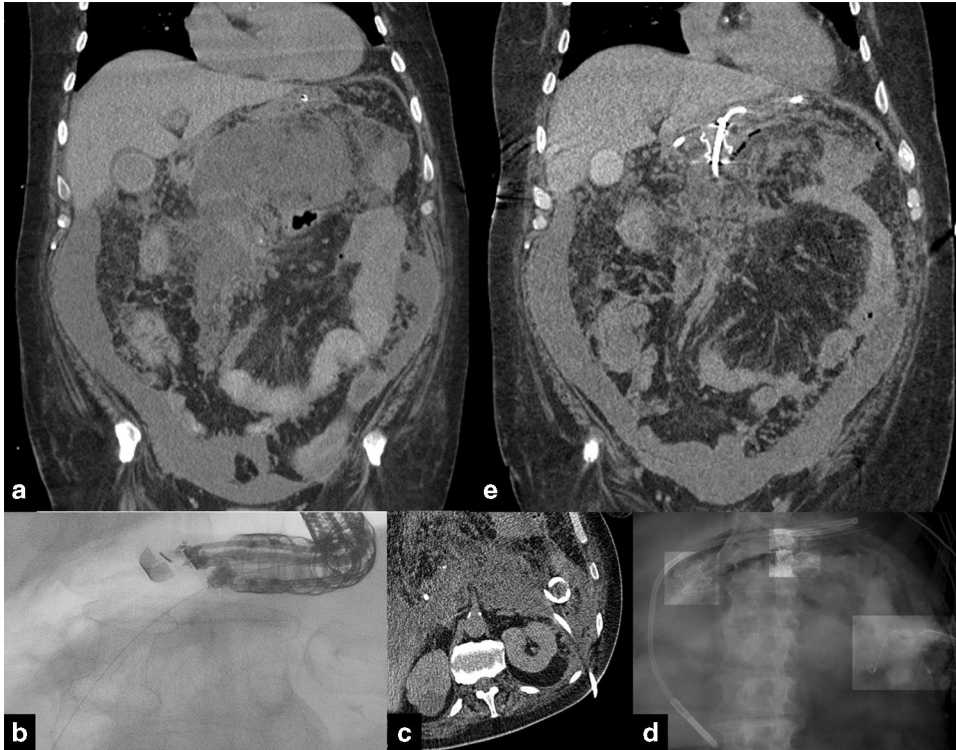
Images representing serial interventions on a 69-year-old male with severe acute pancreatitis due to gallstones, resulting in acute respiratory failure requiring mechanical ventilation and acute renal failure requiring CRRT. Three weeks after presentation, CT showed poorly demarcated acute necrotic collection with ascites (a); the patient decompensated further with hemodynamic instability, and underwent endoscopic transluminal drainage with lumen-apposing metallic stent (b), followed by left retroperitoneal percutaneous catheter drainage (c), with resolution of hemodynamic instability and decrease to intermittent hemodialysis; after endoscopic transluminal necrosectomy and placement of second transgastric lumen-apposing metallic stent (d), repeat CT showed significant decrease in size and extent of acute necrotic collection (e)
